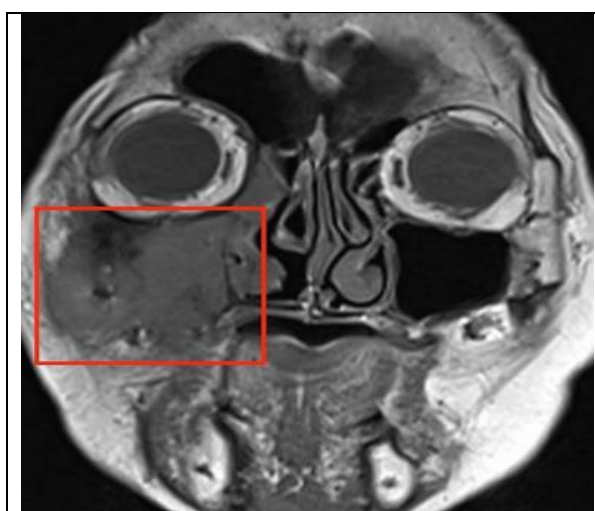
T1-weighted coronal MRI
